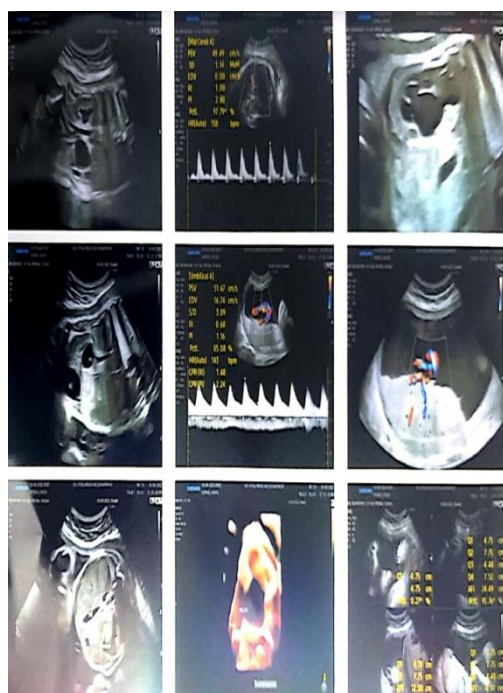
Anomaly Scan Doppler study
